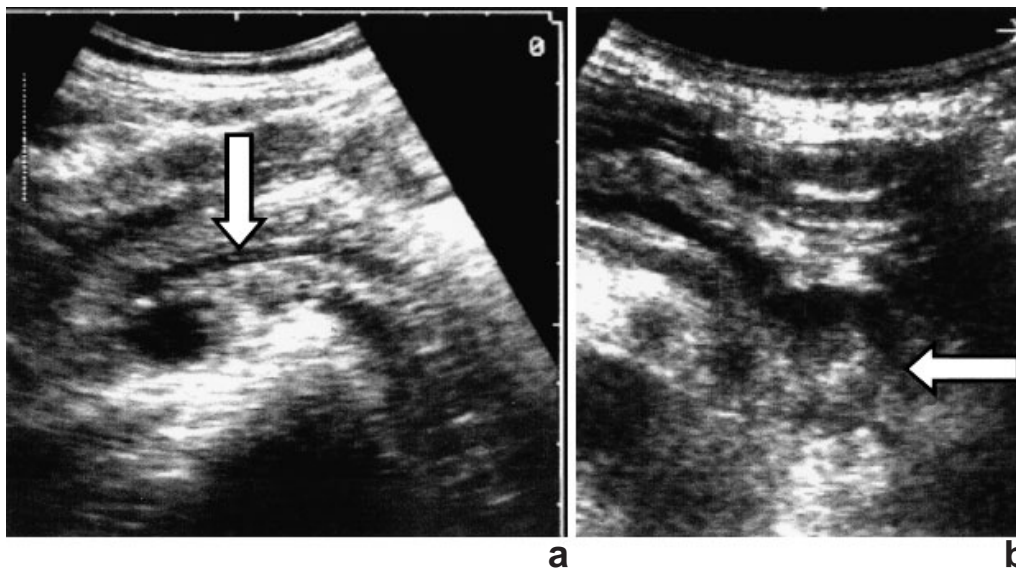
A case with pancreatic tail cancer. (a) In June 1990, a slight dilatation (2.5 mm) of the main pancreatic duct (arrow) was detected by sonography, but dynamic CT revealed no significant sign. In December 1991, the diameter of the main pancreatic duct had increased to 7 mm by sonography and endoscopic-retrograde pancreatography with pancreatic juice cytology was performed. However, no malignant sign was revealed except for the dilatation of the main pancreatic duct. (b) In September 1992, a round tumor 45 mm in diameter (arrow) was detected in the pancreatic tail with main pancreatic duct dilatation in the proximal part. In November 1992, pancreatic ductal adenocarcinoma in the tail of the pancreas was surgically resected by distal pancreatectomy.
